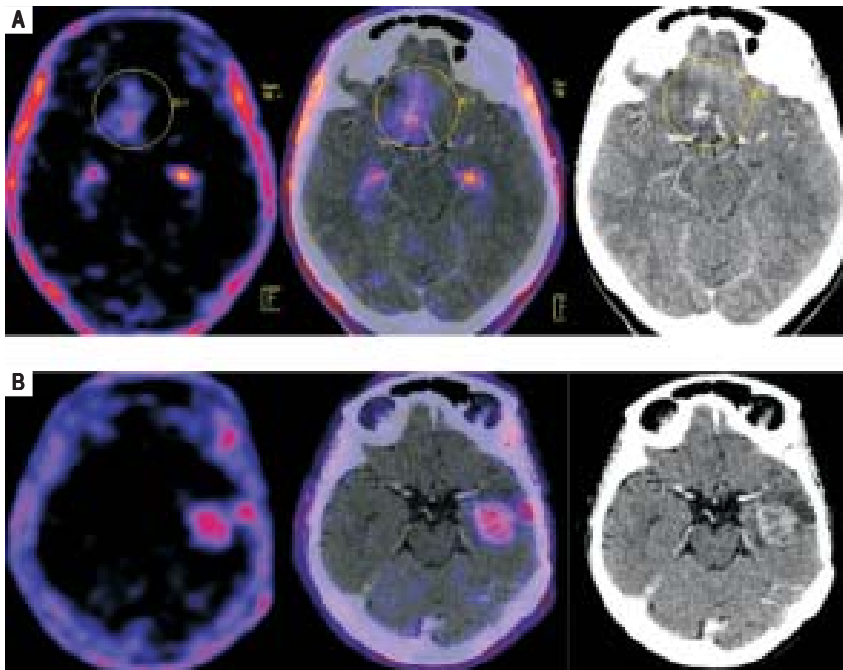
A. ^{11}C -Choline PET-CT. 36 y.o. female with brain glioma: high oxidative activity in right frontal lobe. B. ^{18}F -FLT PET-CT. 52 y.o. female with high-grade astrocytoma: high uptake seen in two lesions of the left temporal lobe associated with post I.V. contrast enhancement and edema.
